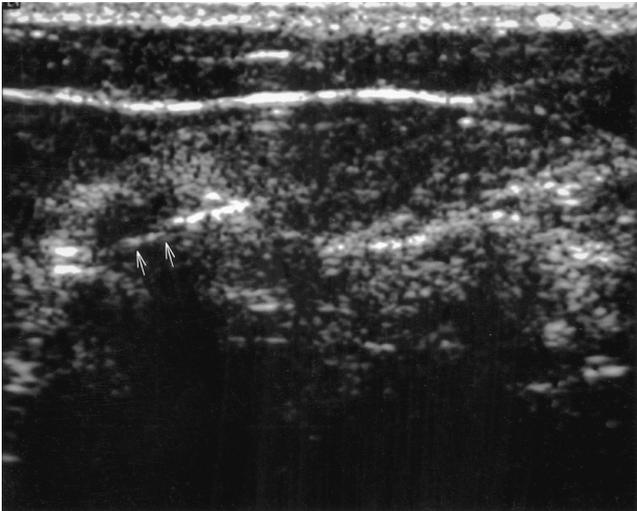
Ultrasonogram confirming that the needle (arrows) traversed the mass.
